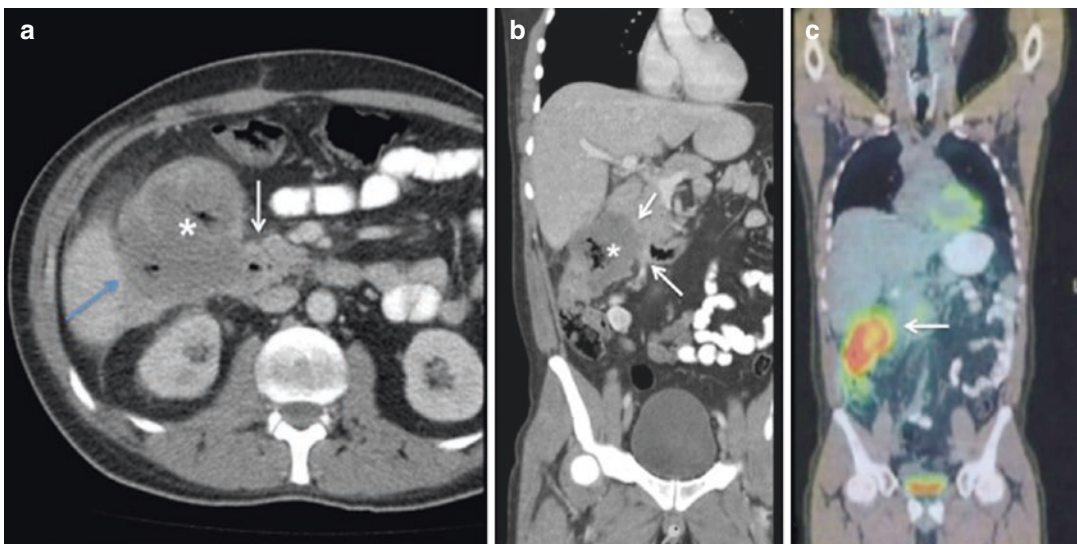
Abdominal and pelvic multidetector computed tomography (MDCT) in a patient with a large colonic tumor (asterisk), which involves duodenum and pancreas (white arrow) and segment VI of the liver (blue arrow)
